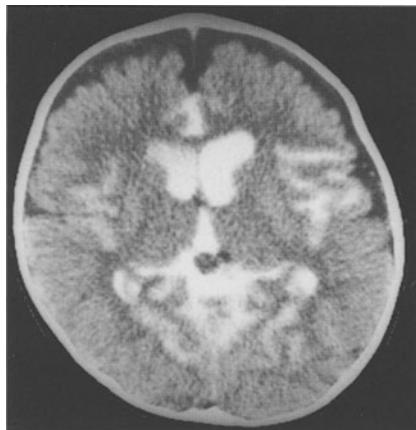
A 1-year-old baby boy with superior vena cava thrombosis and external hydrocephalus. CT scan after lumbar injection of contrast. The anterior dilated spaces are not opacified whereas the ventricles and the sylvian fissures are
